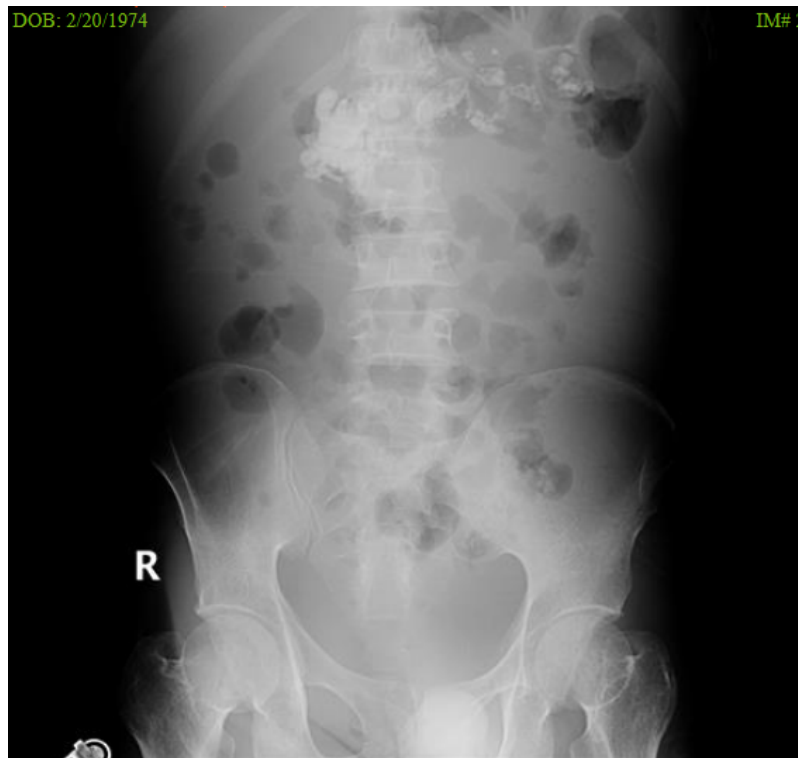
Calcification of pancreas appear in abdominal X-ray
